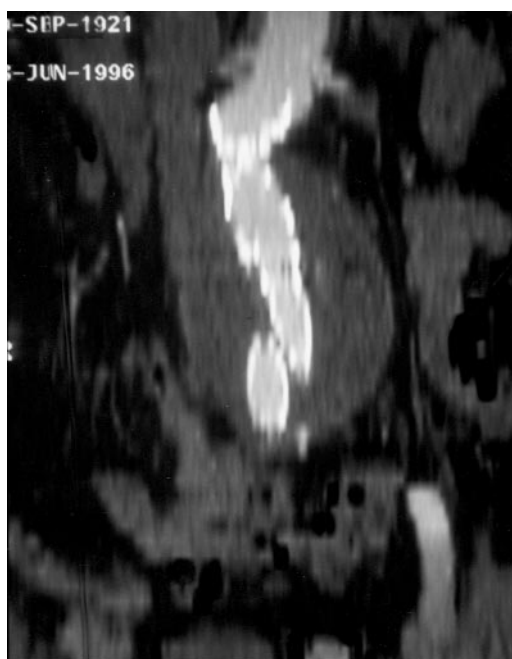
Postprocedural computed tomography reconstruction showing the position of the implanted stentgraft in a longitudinal view and the tortuosity of the aorta at the level of the upper limit of the stent.
